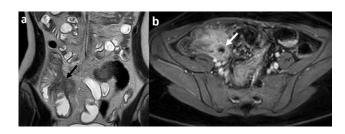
A 16-year-old girl with known Crohn's disease. Coronal SSTSE T2-weighted image (a) shows an enteric fistula (black arrow) and axial contrast-enhanced T1-weighted with fat suppression image shows an abscess formation with peripheral enhancement (white arrow).
